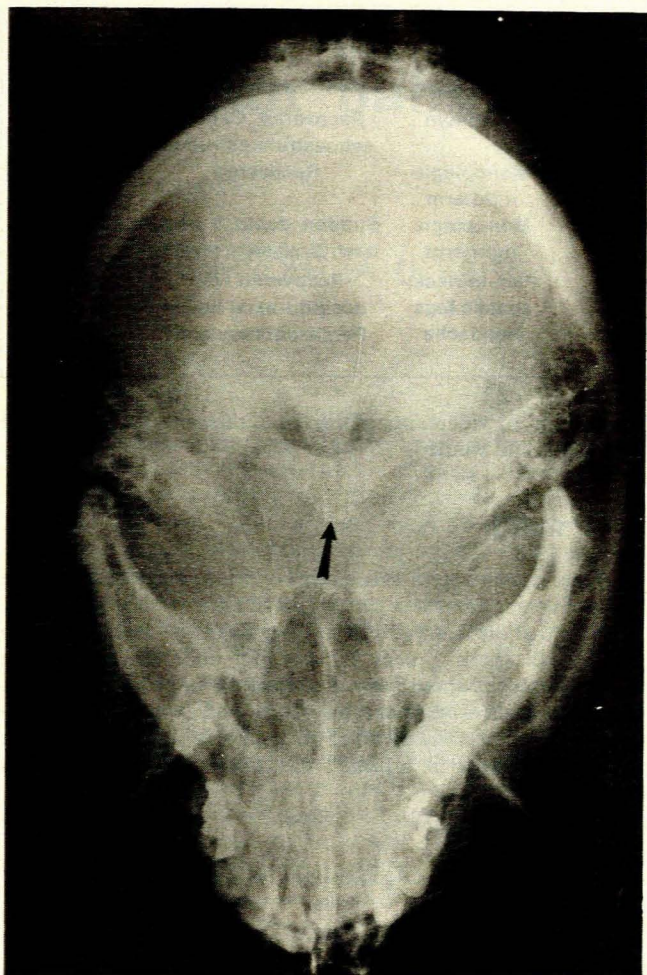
Basal radiograph showing a fracture to the right of the midline (arrow) in the anterior arch of the atlas.
